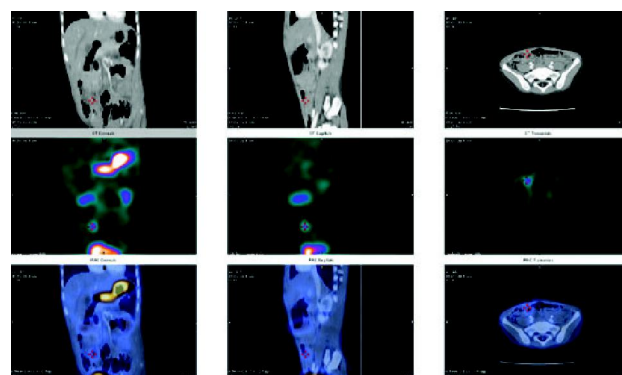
SPECT/CT images of same patient (Fig. 2) showing Meckel's diverticulum with better underlying anatomical localization.
